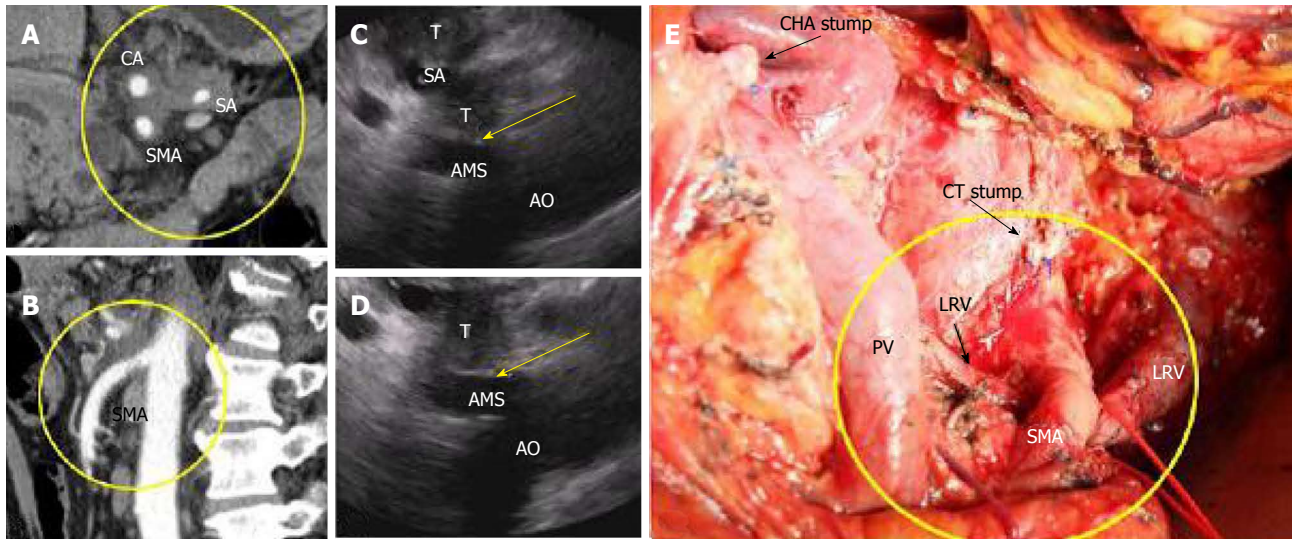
In this 65-year-old man (case #10), pancreatic body DAC with 360° celiac (CA), splenic (SA) and superior mesenteric artery (SMA) encasement was established on CT (A, B), but endoUS data did not confirm this conclusion, finding a plane between the tumor and the SMA (C, D, arrows). AMS: Arteria mesenterica superior, AO: Aorta, T: Tumor. Distal pancreatectomy with excision of the celiac artery (CA) and left adrenalectomy were performed, and no SMA involvement was identified during surgery (E). The level of resection was R1 because of the contact of the SMA with the tumor. CHA: Common hepatic artery; CT: Celiac trunk; LRV: Left renal vein; PV: Portal vein.
